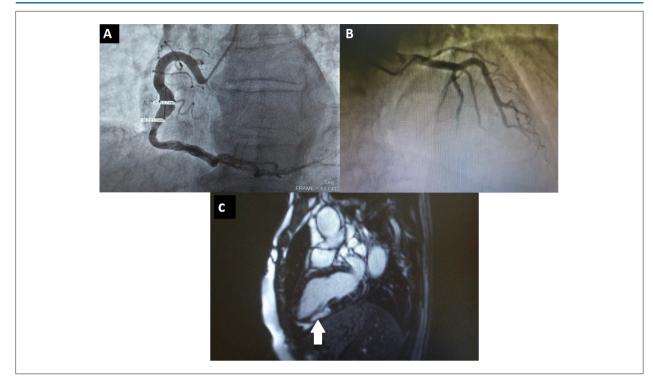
A. Coronary angiography. Frame showing the right coronary with aneurysm, 8.0-mm wide and 16.2-mm long; B. Coronary angiography. Frame showing the left anterior descending coronary artery TIMI 3 flow; C. Cardiac magnetic resonance imaging. Frame showing late gadolinium enhancement in the apical inferior segment, ischemic pattern.
